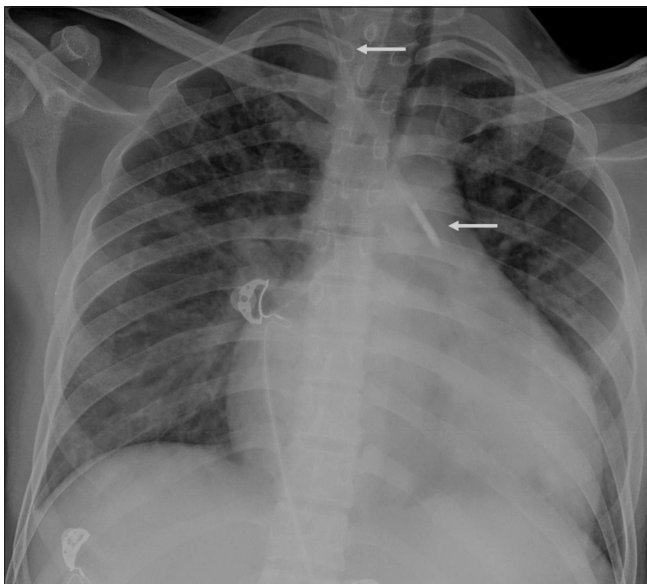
Frontal chest radiograph shows an abnormally medial course of the catheter (arrows) in a case of inadvertent carotid cannulation
